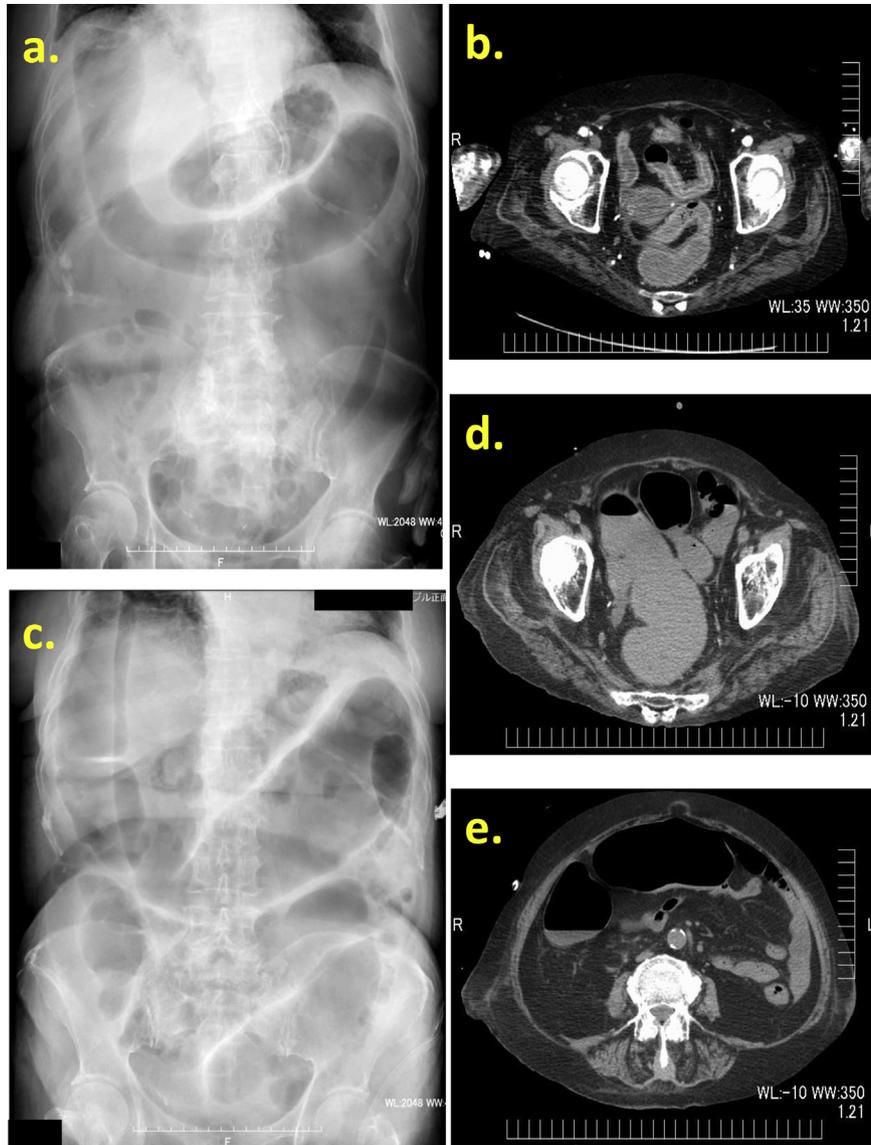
Radiographic findings. a) Abdominal radiography at day 32: marked dilatation of ascending, transverse colon are detected. b) Abdominal computed tomography at day 32 (with contrast enhancement): the wall thickening of sigmoid colon are detected. c) Abdominal radiography at day 37: dilatation of ascending, transverse, and sigmoid colon was markedly worsened. d, e) Abdominal computed tomography (plain) at day 40: marked dilatation of sigmoid colon (d) and transverse colon (e) are detected.
